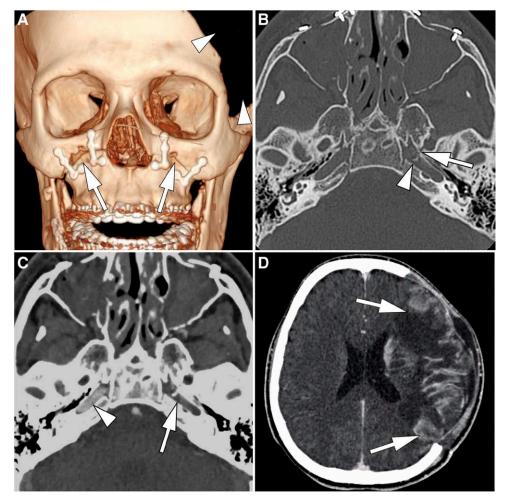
Skull base fractures and stroke after Le Fort I surgery. Three-dimensional reconstruction CT image (A) shows a Le Fort I osteotomy (arrows) and a left craniectomy (arrowheads). Axial CT image (B) shows a skull base fracture involving the left foramen ovale and carotid canal (arrow) with bone fragments inside the left carotid canal (arrowhead). Axial angiographic CT image (C) shows occlusion of the left carotid artery (arrow). Note the normal right carotid artery for comparison (arrowhead). Axial contrast-enhanced CT image (D) shows early subacute stroke in the left middle cerebral artery territory (arrows) with brain herniation through the craniectomy defect.
